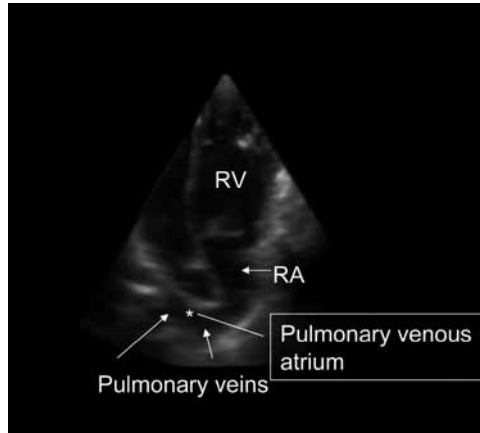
A cross section through the 3D dataset mimicking an apical 4-chamber view in a patient with TGA after Mustard repair. The pulmonary veins are shown along with the connection to the right atrium. Atrial baffles are not seen in this view, because they are in other levels. If one would scroll through the dataset more towards the posterior, the inferior baffle would be seen. Scrolling more anteriorly would show the superior
